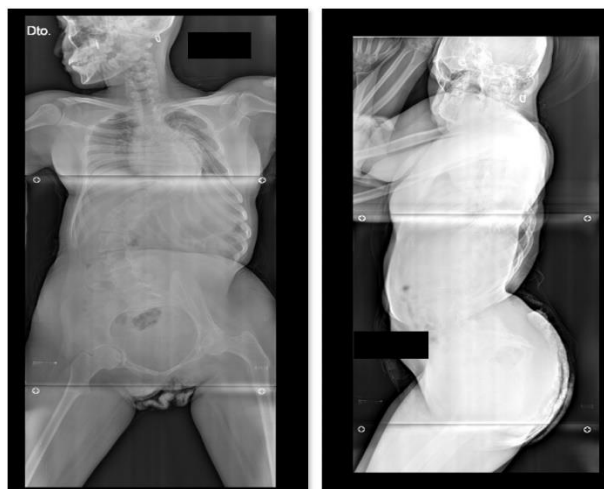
Preoperative Anteroposterior Radiograph (A) and Lateral (B) Showing a Double Major Curve with Pelvic Obliquity.
